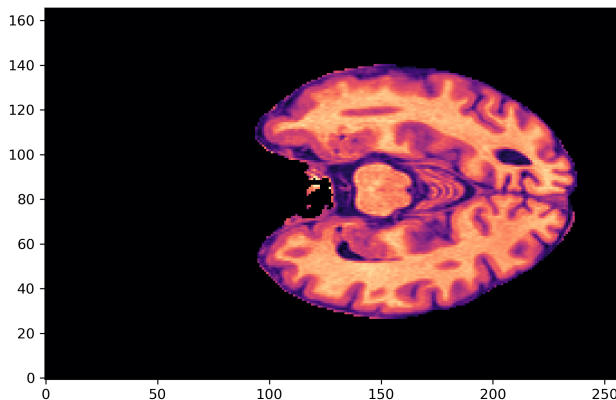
Transversal Layer of an MRI Brain Scan after SynthStrip
